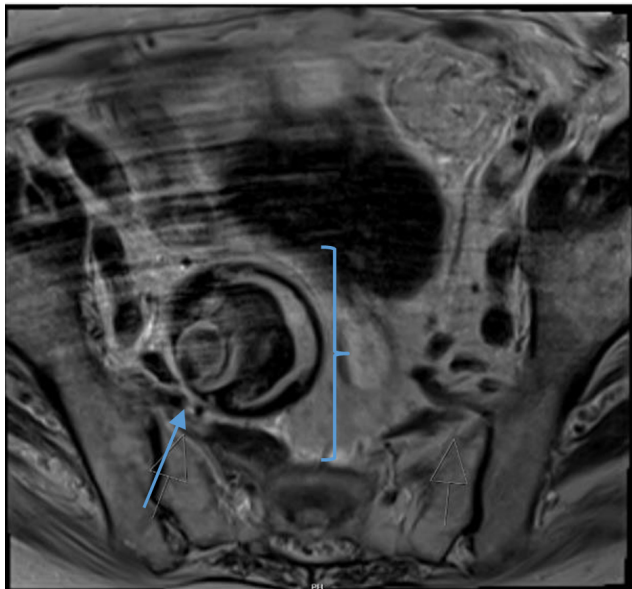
MRI Pelvis T2 Axial. Image showed aneurysm (arrow) exerting mass effect (bracket) on the right lumbosacral trunk L3, L4, L5, and S1 nerve.
